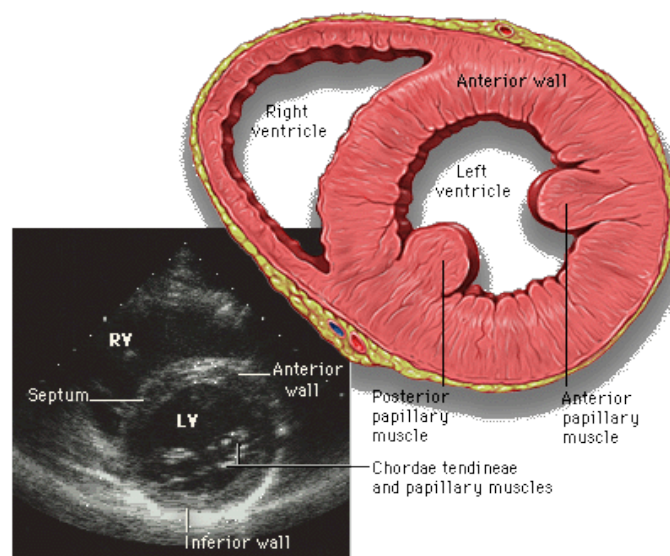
Normal parasternal short axis view (papillary muscle level) .(Feigenbaum2010).
